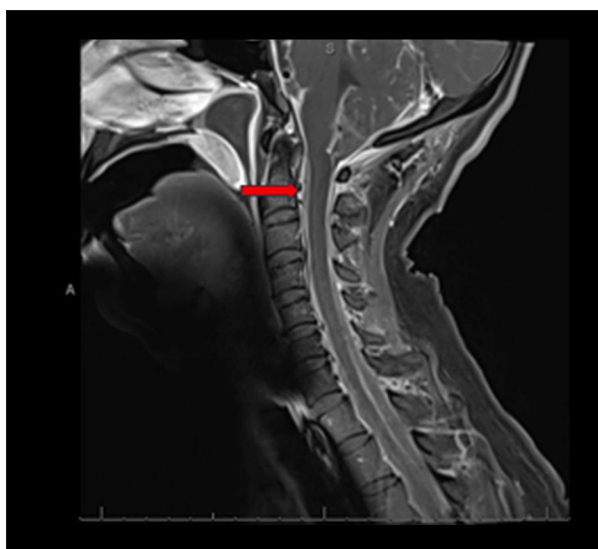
Magnetic resonance imaging of the cervical spinal cord demonstrating hyperintensity on T2-weighted imaging (red arrow).
